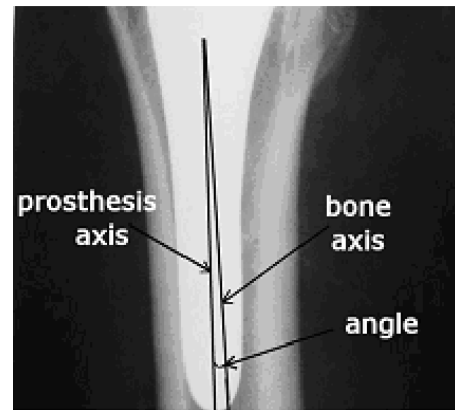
Radiographic hip prosthesis image with marked angle between the bone and the prostheses stem axis.
